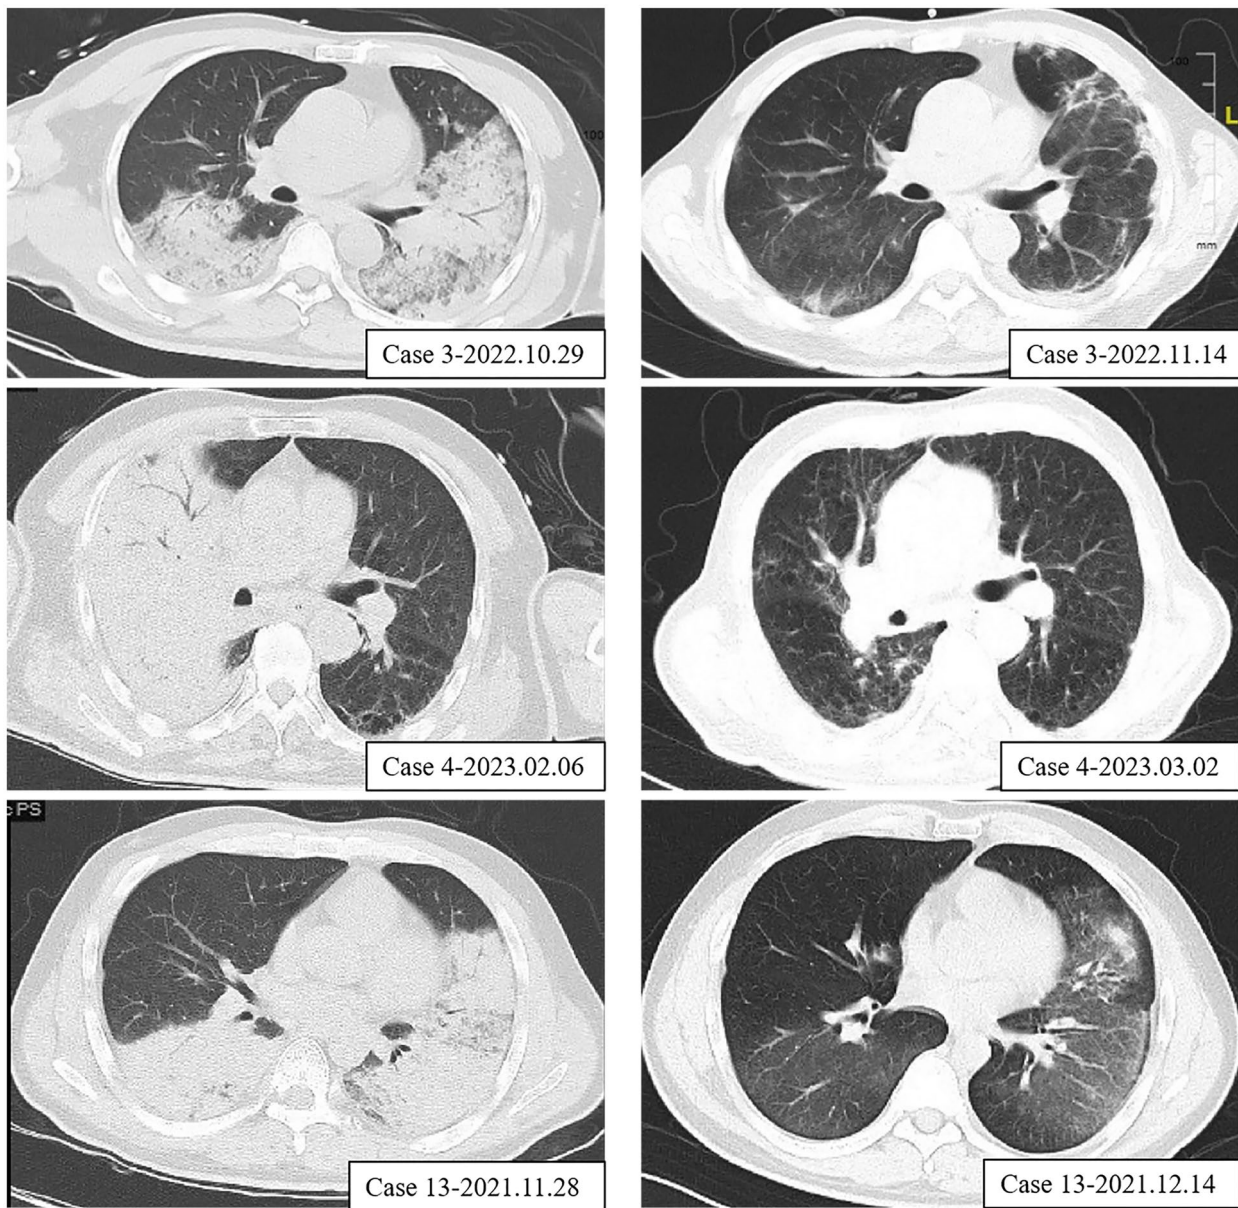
Chest computed tomography images of patients with *Chlamydia psittaci* before and after the treatment of tetracycline.
